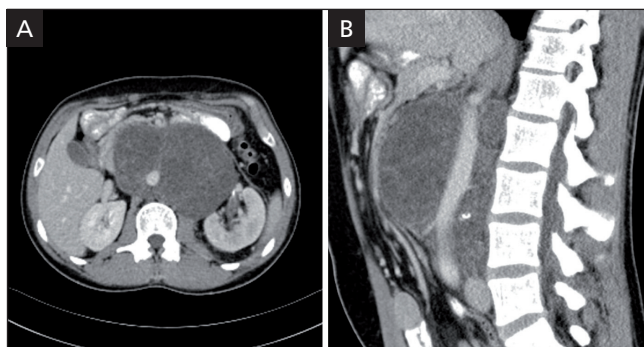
Computed tomography angiography of the abdomen revealing retroperitoneal lymphadenopathy encapsulating subrenal aorta and inferior vena cava. (A) Cross-section of the abdomen with massive retroperitoneal lymphadenopathy encapsulating inferior vena cava. (B) Transverse section of the abdomen with massive retroperitoneal lymphadenopathy encapsulating subrenal aorta.
